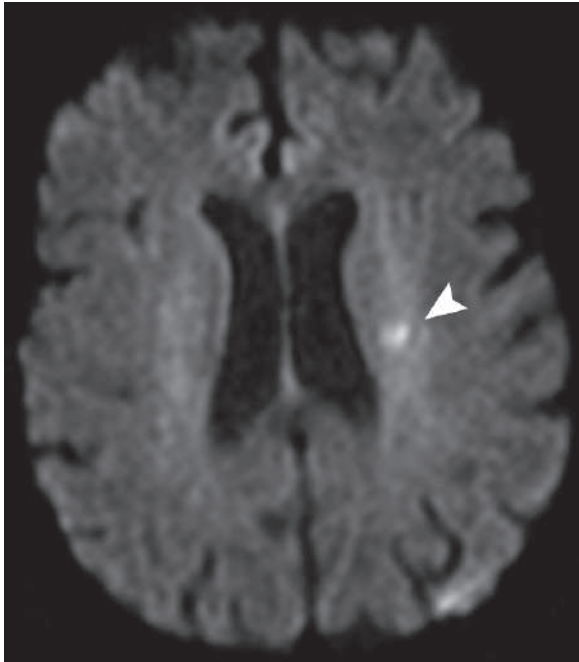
Axial brain DWI shows acute lacunar infarction in the left paraventricular area (*arrowhead*)
